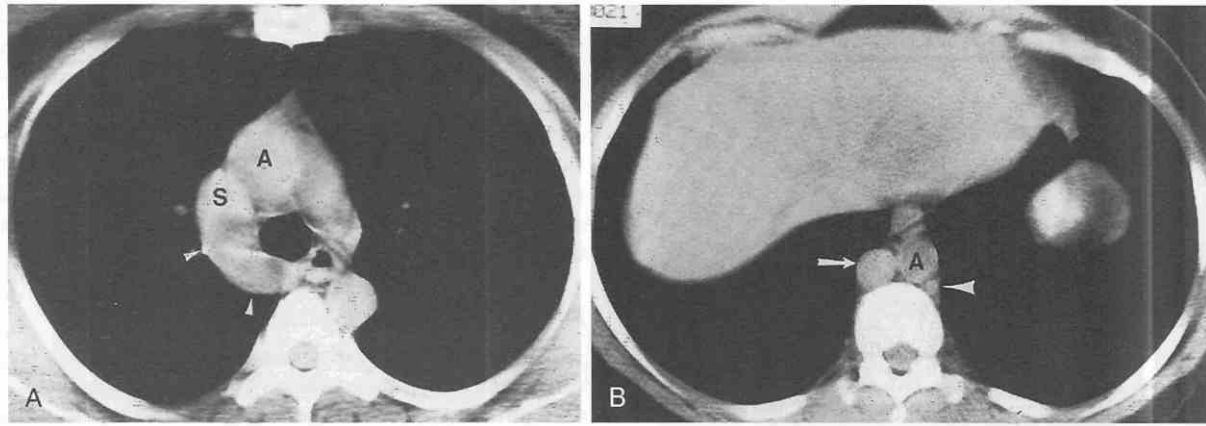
Azygos continuation of interrupted inferior vena cava. *A*, CT shows the dilated azygos vein (arrowheads) as it enters the posterior aspect of the superior vena cava (S). *B*, Caudal CT shows the dilated azygos vein (arrow) near the diaphragmatic hiatus. The hemiazygos vein (arrowhead) is normal. A, aorta.
